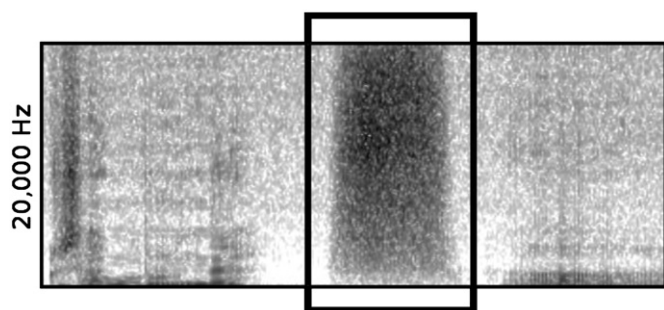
Sonogram showing a representative loud noisy breath intake (marked by box) that exhibits high-frequency noise components up to 20,000 Hz. The breath intake is 451 ms long, the whole sequence is 2.15 s. Note that the breath intake is surrounded by short pauses and followed by a filler [a:].
